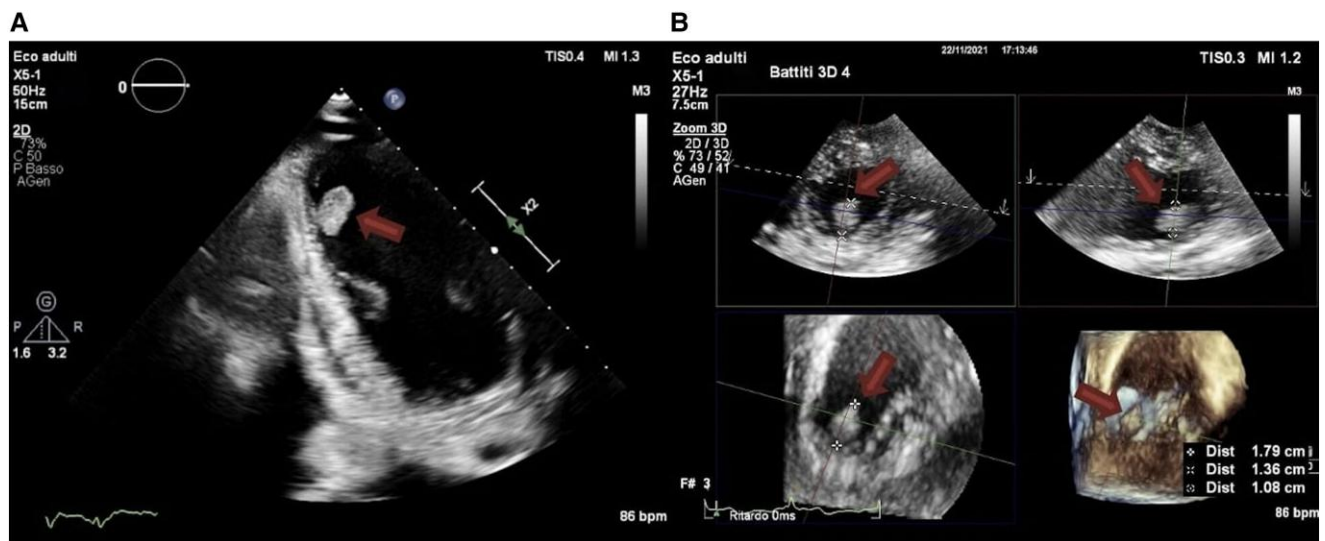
Transthoracic two-dimensional (A) and three-dimensional (B) echocardiography showed an apical thrombus in the left ventricle (arrows).
